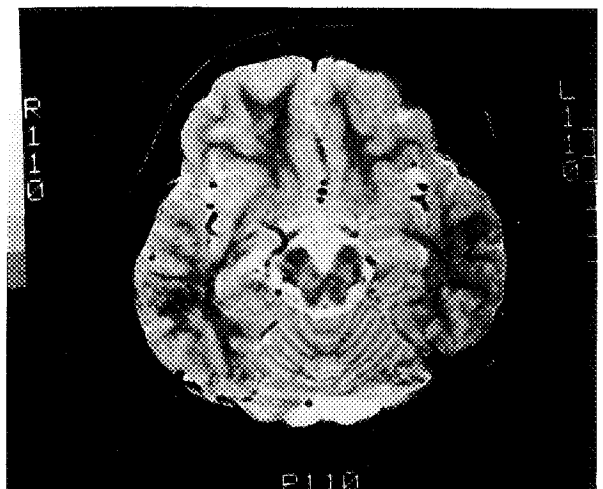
T2-weighted image of Patient 2. Affected bone shows low signal intensity.
